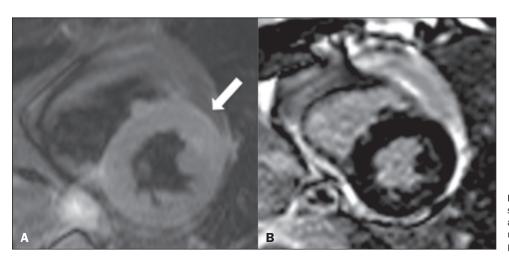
T2-weighted CMR sequences in short-axis views, showing edema in the anterior mid-LV segment (A), without correspondence in the delayed enhancement phase (B).
